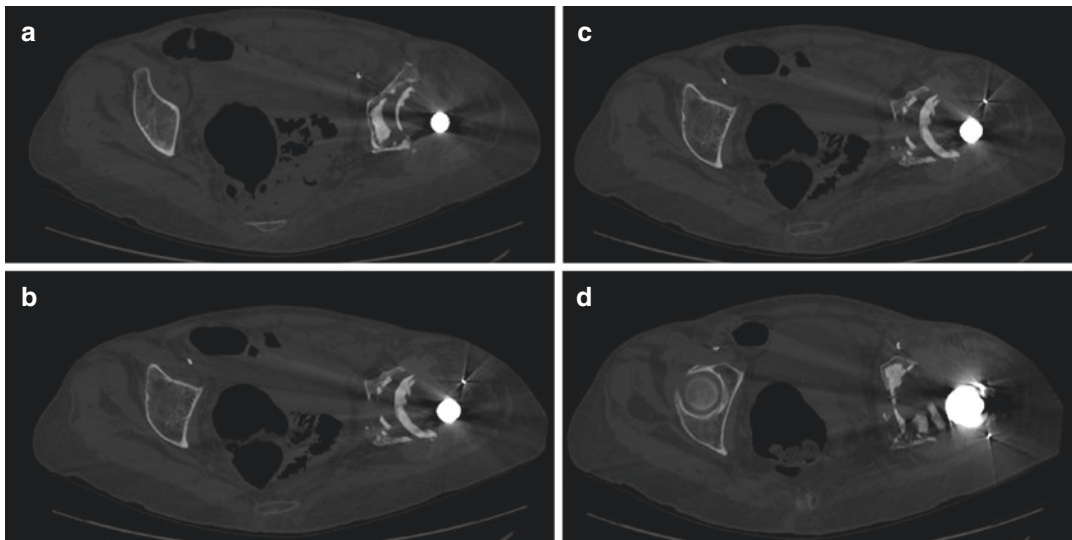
(a–d) Preoperative computed tomography (CT) showed extensive acetabular osteolysis with disruption of the medial wall
